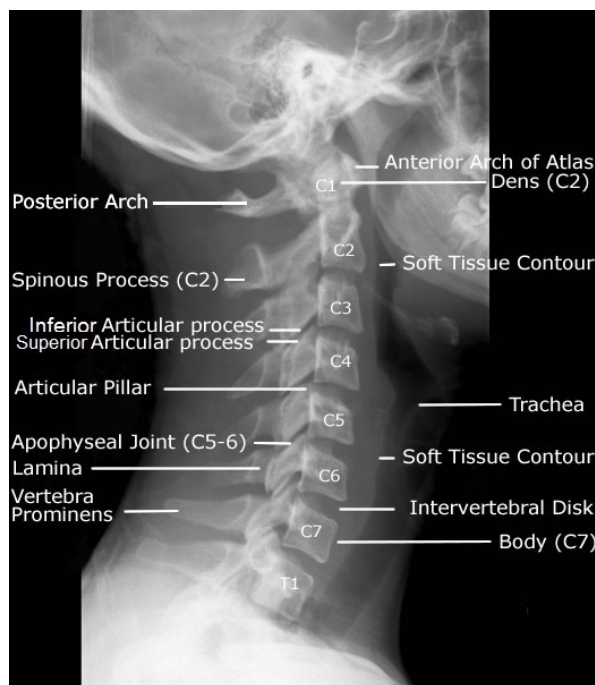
Points of reference for a technical evaluation of X-ray lateral projections of the cervical spine. Image taken from wikiRadiography.
